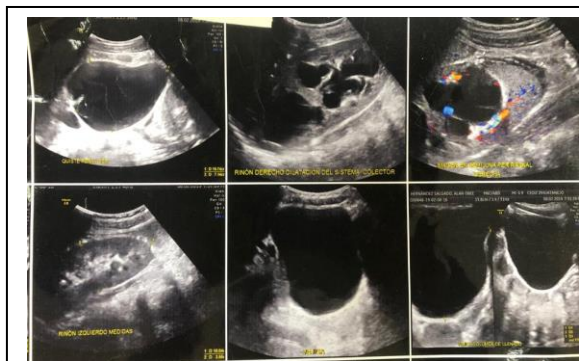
Renal ultrasound with right hydronephrosis.
